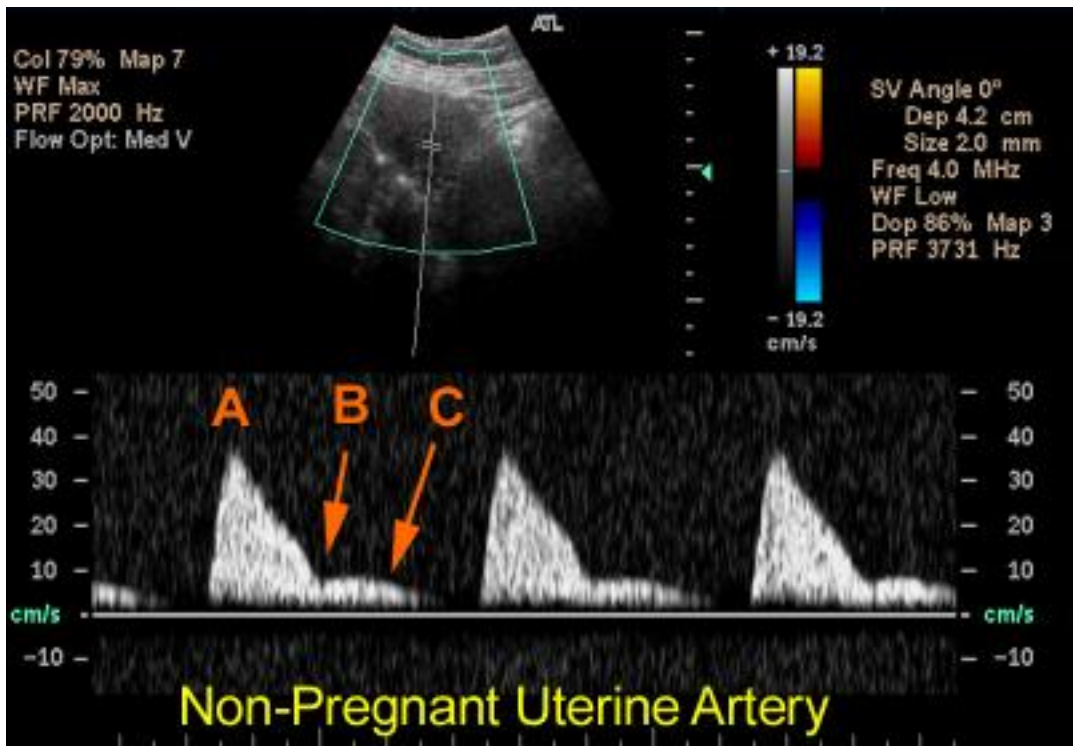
Doppler waveform for a non-pregnant uterine artery
